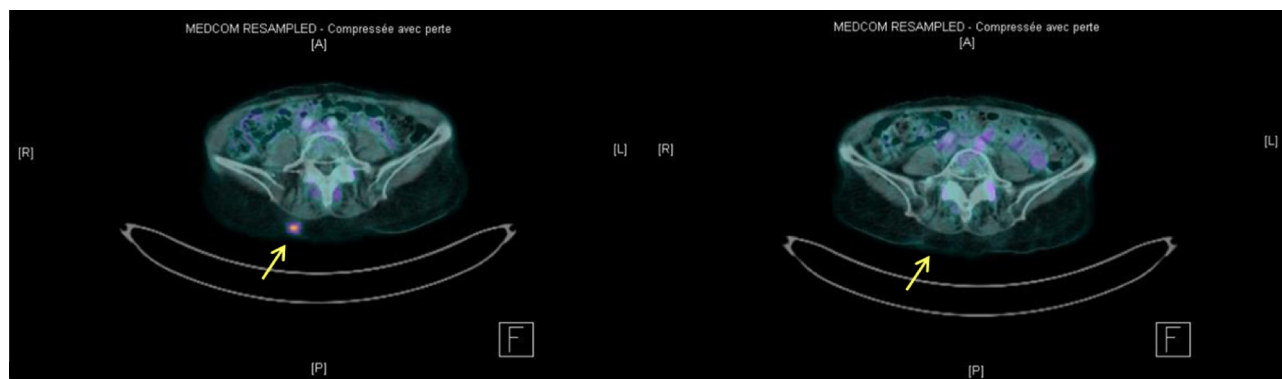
Combined PET/CT evaluation before (left) and after (right) 3-month single agent lenalidomide treatment on second relapse, showing complete disappearance of the right lumbar subcutaneous MCL relapse (arrows).
